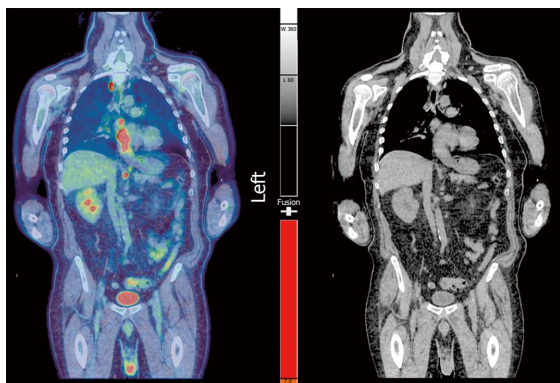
Positron emission tomography-computed tomography image. Positron emission tomography (PET)-computed tomography image of PET positive lower oesophageal tumour with uptake in the primary tumour and also in high paratracheal and coeliac nodes.
